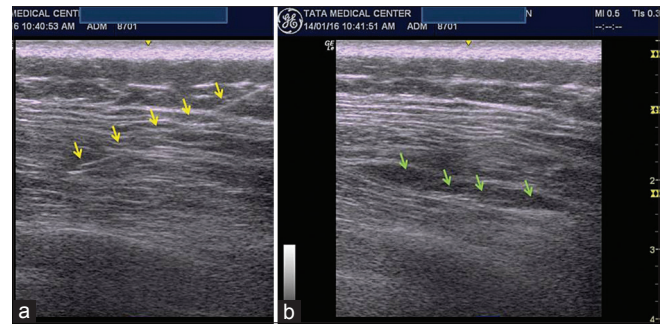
Ultrasound image of LD block: (a) The block needle (yellow arrows) enters the muscle plane. (b) The drug is injected in the plane, separating two muscle layers (green arrows)
